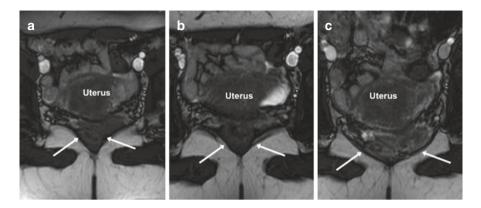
Dynamic MRI coronal planes of the levator ani muscles (*white arrows*). At rest, the levator ani muscles have the aspect of a convex dome. (b) During levator ani contraction (restrain), there is a horizontalisation of muscle fascicles. (c) During Valsalva manoeuvre, bloated muscles allowing for expansion of the pelvic hiatus (Extract from: Deffieux X, Fatton B, Amarenco G, de Tayrac R. Manuel pratique d'urogynécologie, pages 37–52. Copyright © 2011 Elsevier Masson SAS. All rights reserved)
